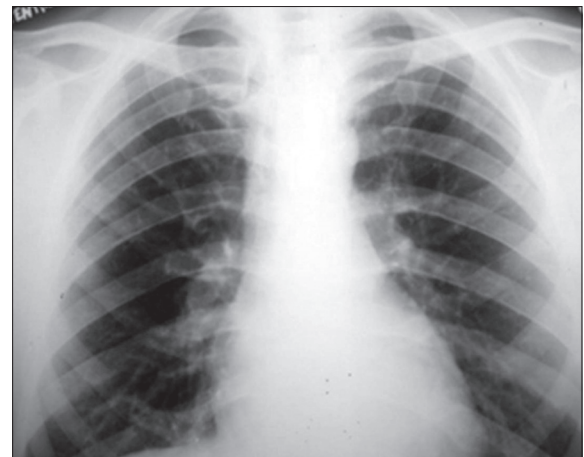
Chest radiograph without evidence of bifid rib
